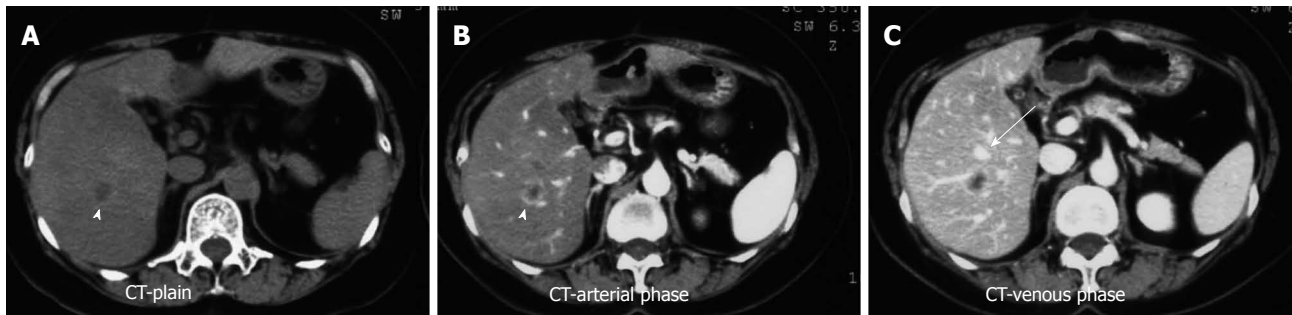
Computed tomography scan findings. A 63-year-old woman with a 1.5 cm metachronous colorectal liver metastasis in the segment 6 close to the right hepatic vein underwent adjuvant chemotherapy after open colorectal surgery and her liver had severe fatty change. Therefore, posterior sectionectomy was applied to her lesion, not right hepatectomy. However, since the lesion is close to the right hepatic vein (RHV), RHV exposure was required for R0 resection.
